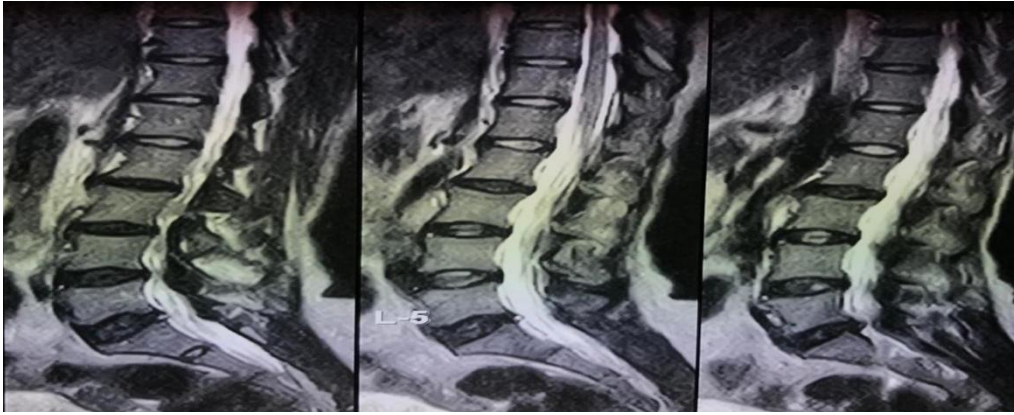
MRI Sagittal view of lumbosacral spine shows multiple level disc-bulge at L3-L4, L4-L5 and L5-S1 disc protrusion.
